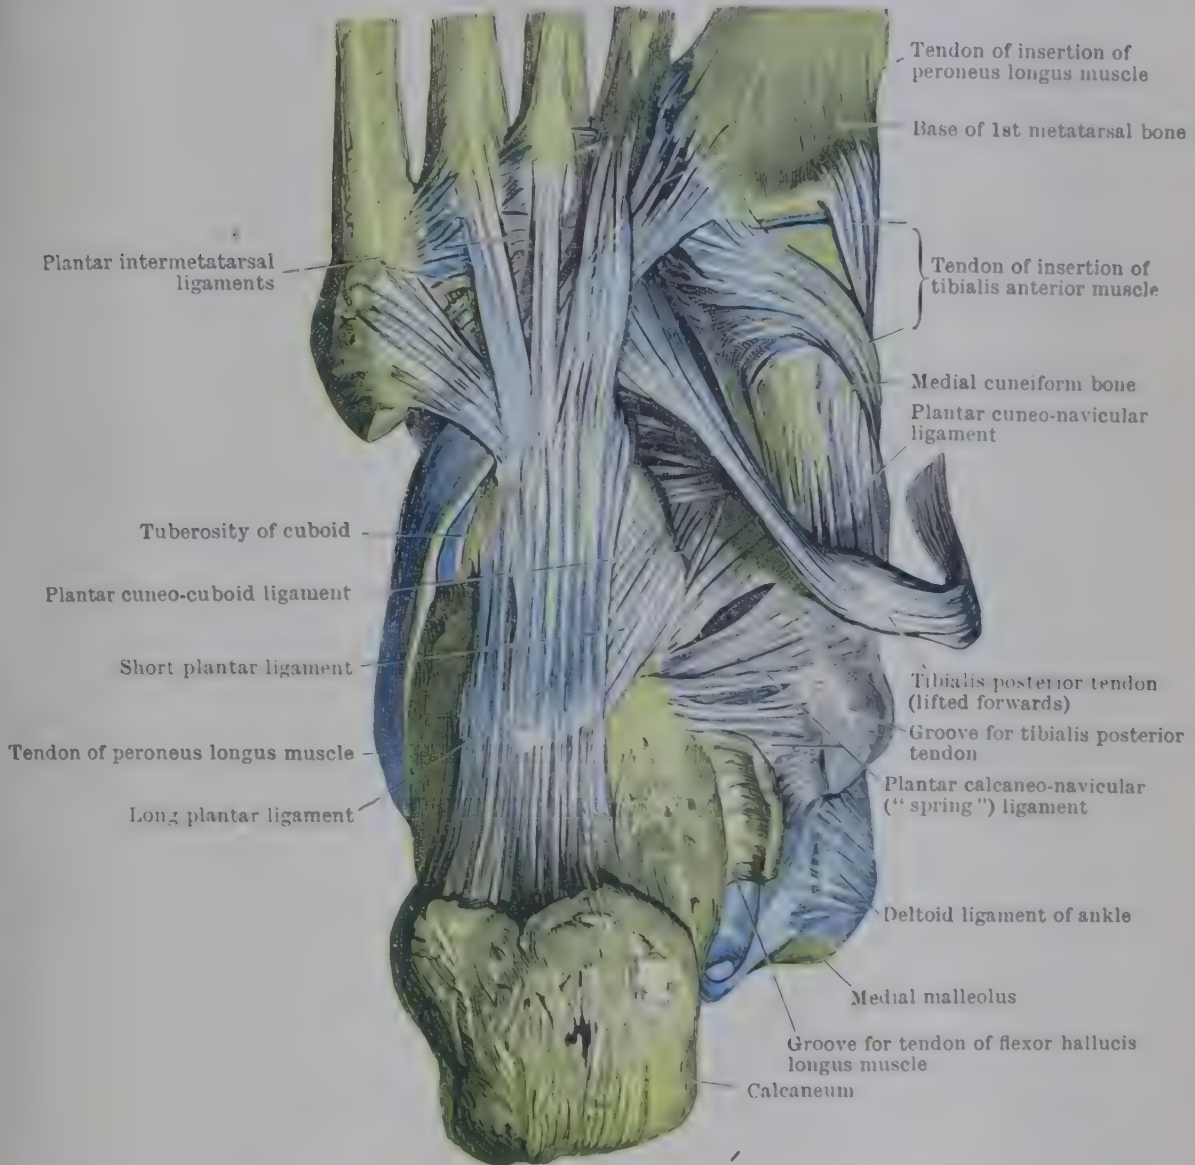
PLANTAR ASPECT OF TARSAL AND TARSO-METATARSAL JOINTS.
